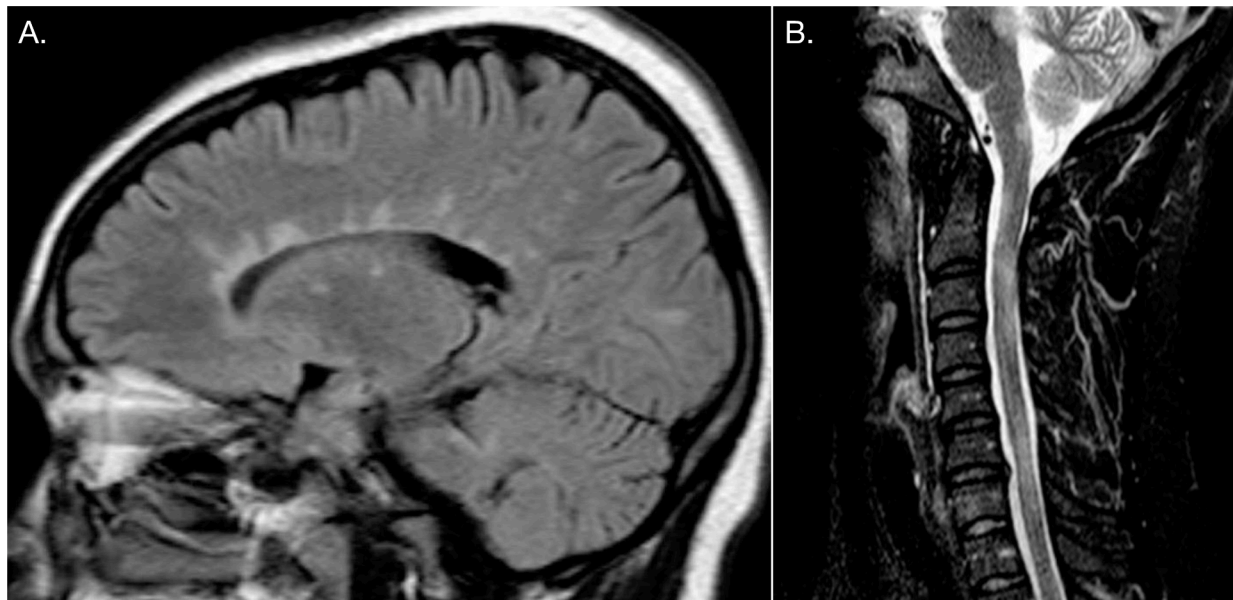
(A) MRI of the brain, T2 weighted imaging performed in 2011 showing numerous periventricular demyelinating plaques. (B) Spinal MRI performed at diagnosis, demonstrating multiple cervical cord lesions.
